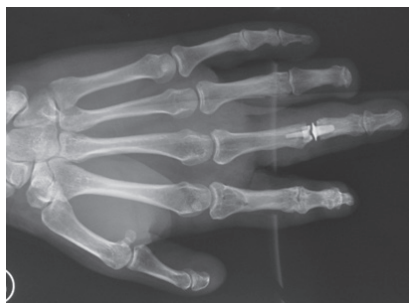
Pre-operative X-ray showing AP
